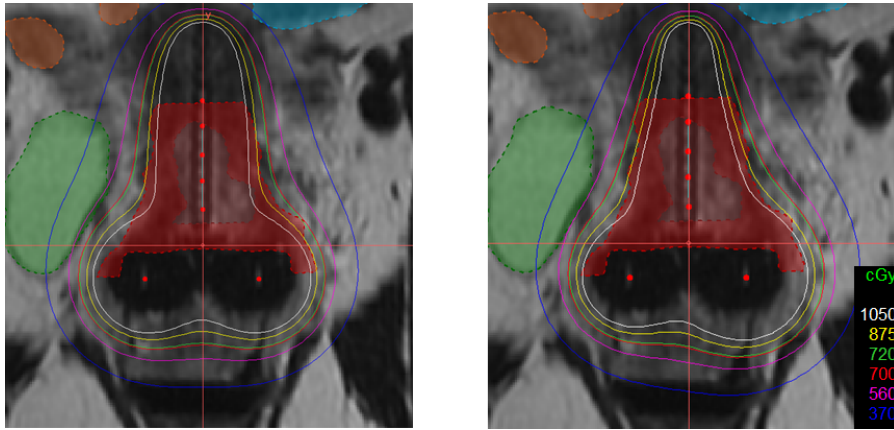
Sagittal slice of an MRI image with the clinical planned isodose lines of the dose distribution (left) and the isodose lines of the automatically generated dose distribution (right) projected on the contoured MRI for a patient. The high-risk clinical target volume (HR-CTV) is shown in red. The automatically generated plan shows a similar pear shape as the clinical plan.
